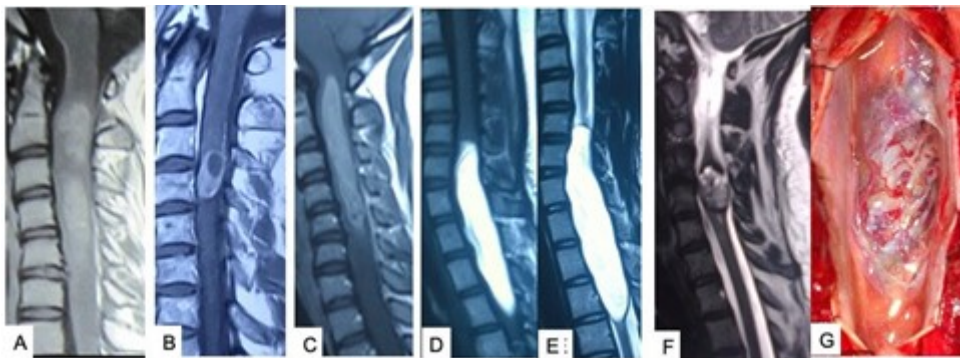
MRI of spine (sagittal sections) showing intramedullary spinal tumours: (A) long-segment cervical ependymoma; (B) cervical haemangioblastoma; (C) cervical astrocytoma; (D,E) cervicodorsal lipoma; and (F) cervical cavernoma. (G) Intraoperative picture of cervical cavernoma after durotomy in patient in (F). Source: Figure by authors.
